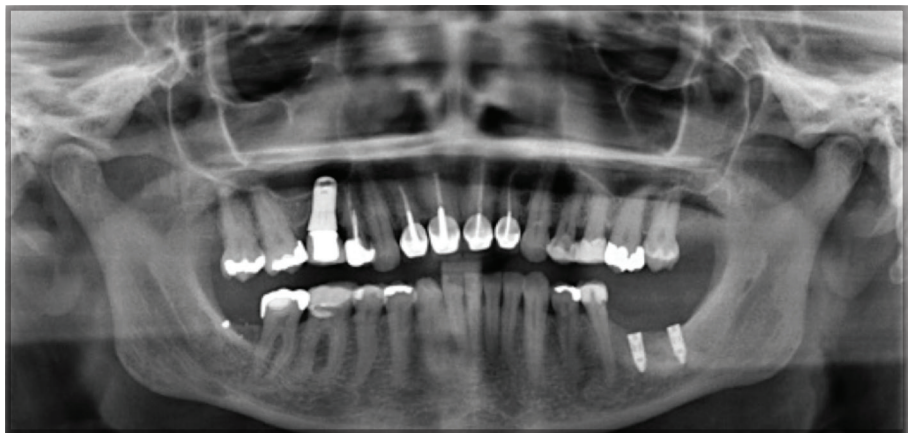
Case 2. Panoramic radiograph showing 2 implants and the perforation of the lingual plate.
